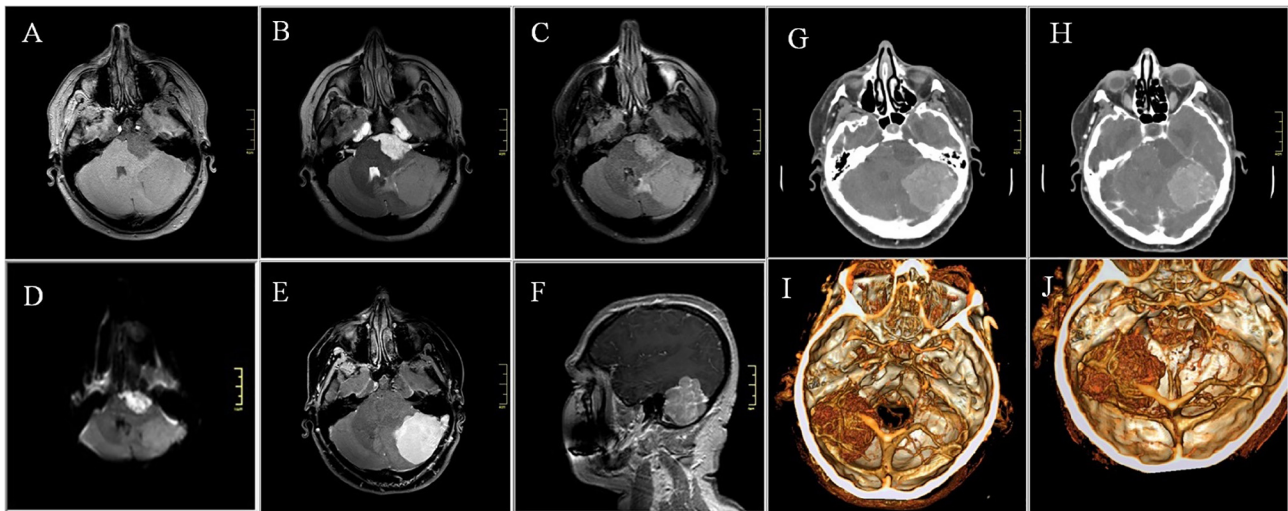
Pre-operative magnetic resonance images (MRIs; A–F) and computed tomographic (CT) angiograms (G–J), showing a giant left-sided cerebellar tentorial meningioma with supra-subtentorial growth and a relatively large epidermoid cyst on the left side of the cerebellopontine angle, extending into the prepontine cistern, clivus and parasellar region. A. T1-weighted MRI. B. = T2-weighted MRI. C. Fluid-attenuated inversion recovery image. D. Diffusion-weighted imaging (DWI). E. T1-weighted MRI with gadolinium (Gd) enhancement, axial projection. F. T1-weighted MRI with Gd enhancement, sagittal projection. G and H. Native CT images. I and J. Three-dimensional CT reconstruction.
